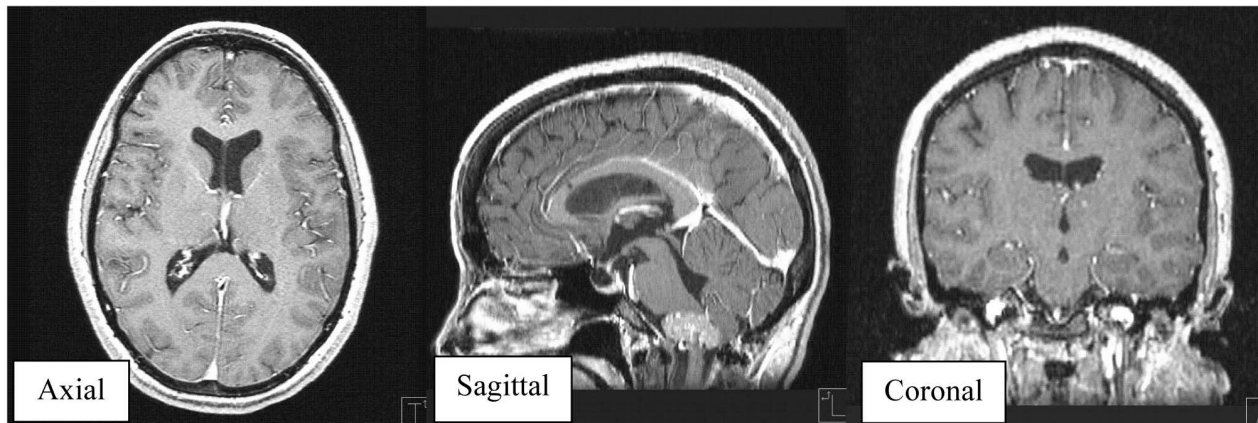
An Example of MRI Images
